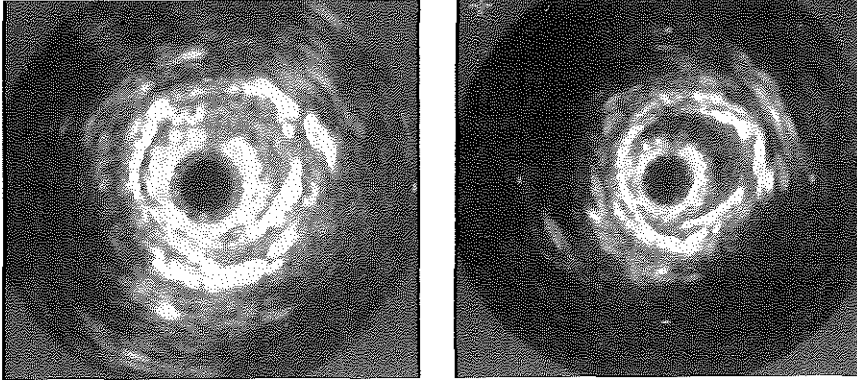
Corresponding intravascular ultrasound cross-sections from the iliac limb of an Ancure aorto-uni-iliac stent-graft showing stenosis and folding of abundant graft material. Although some folding remained, the result was considered satisfactory. The patient developed graft thrombosis a few hours after the intervention; re-intervention failed and the prosthesis was explanted. Calibration = 5 mm.
